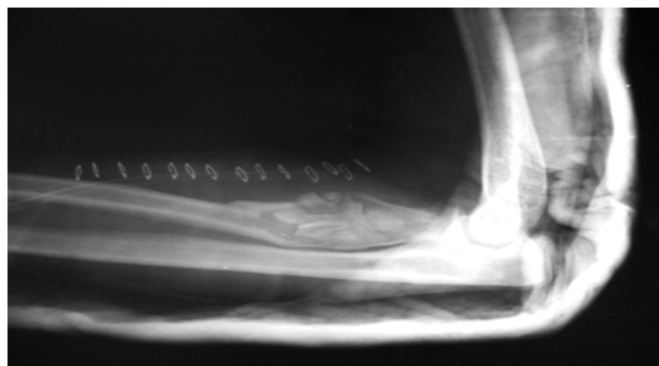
5 Post Operative Xray after Curettage and bone grafting
